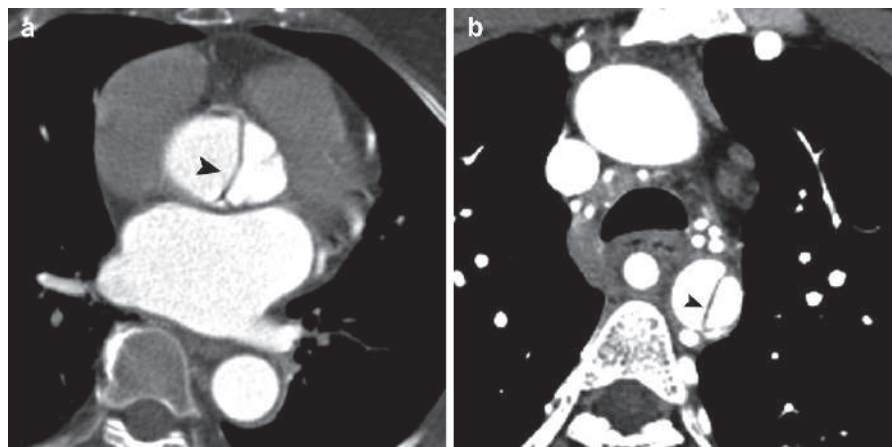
Axial cardiac CTA of two different patients with aortic dissection Stanford type A (a) and Stanford type B (b) shows the classic intimal flap (arrowheads) separating the true from the false lumen
